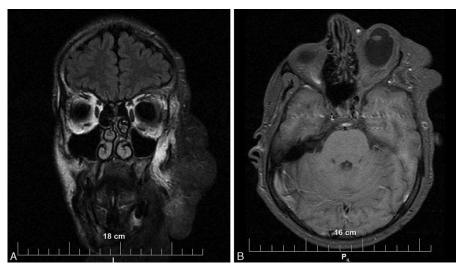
Craniofacial MRI. (A) Axial view: deforming plexiform neurofibroma arising from the left side of the face giving (B) coronal view: homolateral eye dislocation.
